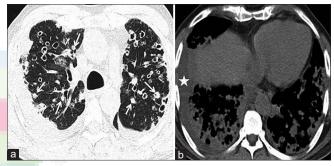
(a) High-resolution computed tomography scan chest demonstrates bilateral multiple cysts of variable sizes and shapes interspersed with surrounding nodules (arrows), (b) soft tissue window shows minimal right pleural effusion (star), and involvement of both lower lobes
